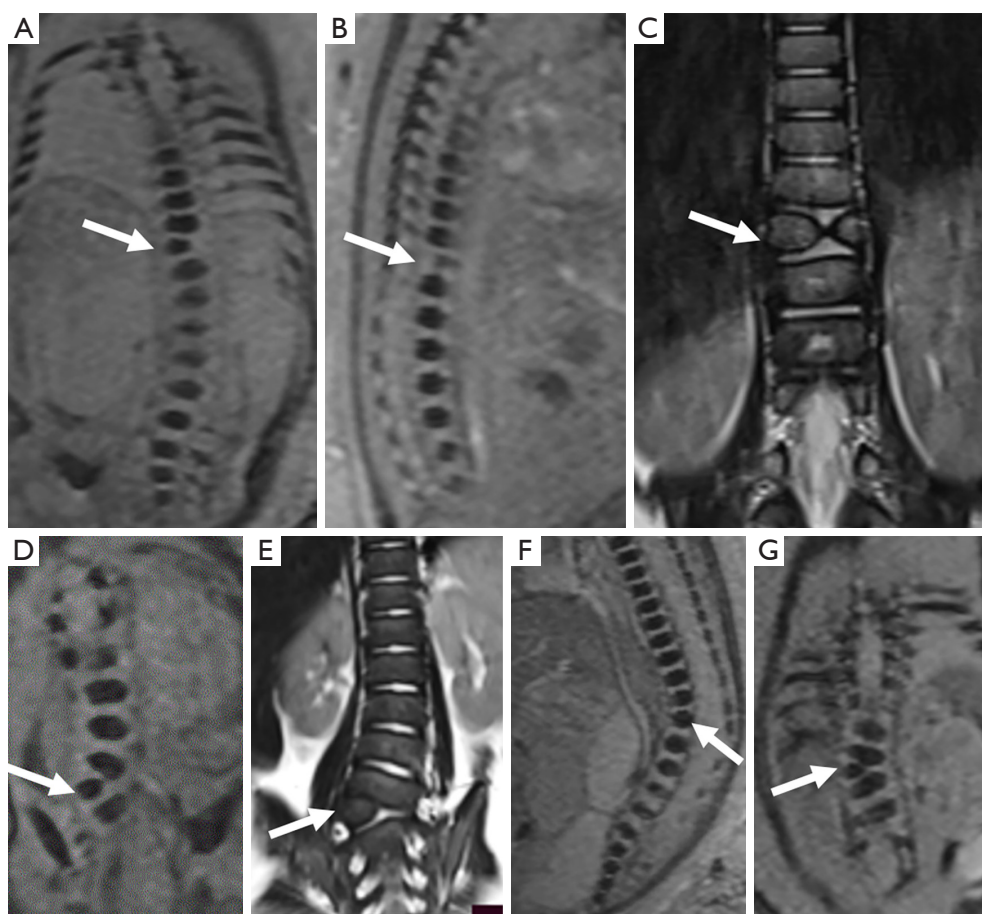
Fetuses with vertebral anomalies. (A-C) Case 56, 31 weeks, T11 was wedge-shaped in coronal and sagittal SWI images (A, B, arrows), diagnosed hemivertebra on prenatal MRI and proved to be butterfly vertebra (C, arrow) at 3 years on postnatal coronal T2WI; (D-E) Case 101, 33 weeks, L5 hemivertebra on prenatal MRI (D, arrow), consistent with postnatal coronal T2WI (E, arrow) at 7 months; (F-G) Case 96, 39 weeks, fetus suspected sacrococcygeal vertebra irregularity in morphology by US showed L2 hemivertebra (G, arrow) with kyphosis (F, arrow) in SWI images. SWI, susceptibility-weighted imaging; MRI, magnetic resonance imaging; T2WI, T2-weighted imaging.
